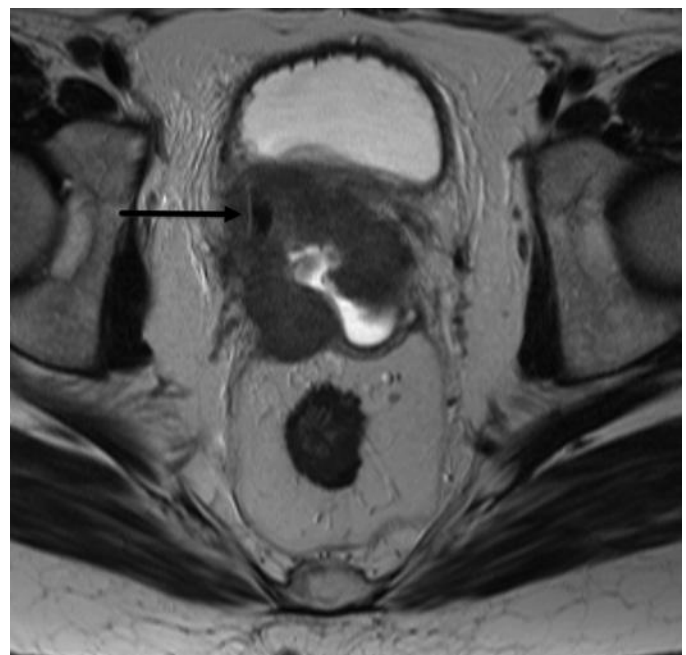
Stage IIIB cervical cancer. Axial T2-weighted image shows an irregular mass extending beyond the cervix into the parametrium bilaterally. Right hydronephrosis was present (not shown) with a stent in the right ureter (arrow). The mass appears to be contiguous with the bladder wall; cystoscopy revealed external mass effect, but no invasion into the bladder.
